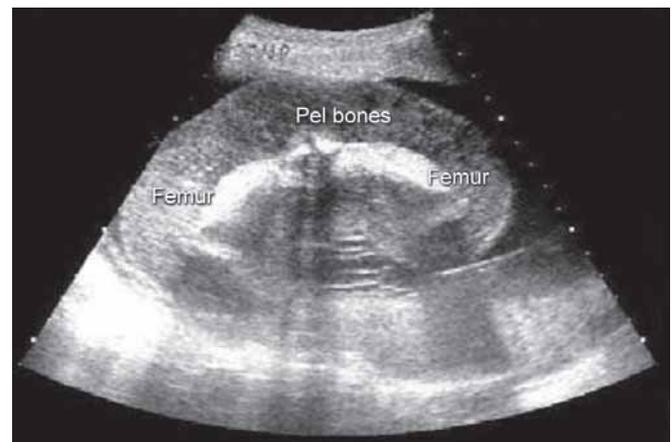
Sonography showing pelvis of acardiac fetus
